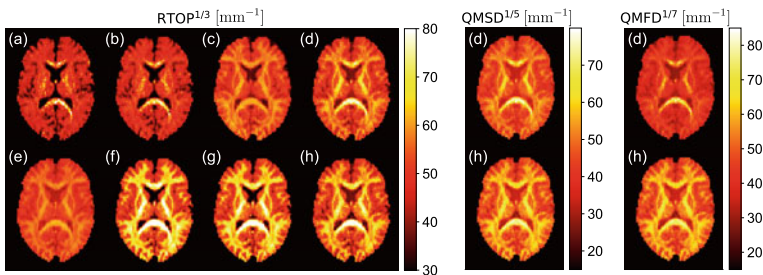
Visual inspection of the measures on in vivo human brain data estimated using various approaches: a DTI ($b = 1000$ s/mm²), b DTI ($b = 1400$ s/mm²), c RBF, d single-shell ($b = 3000$ s/mm²), e 3D-SHORE, f MAP-MRI, g MAPL and h stretched-exponential ($b = 3000$ s/mm²)
